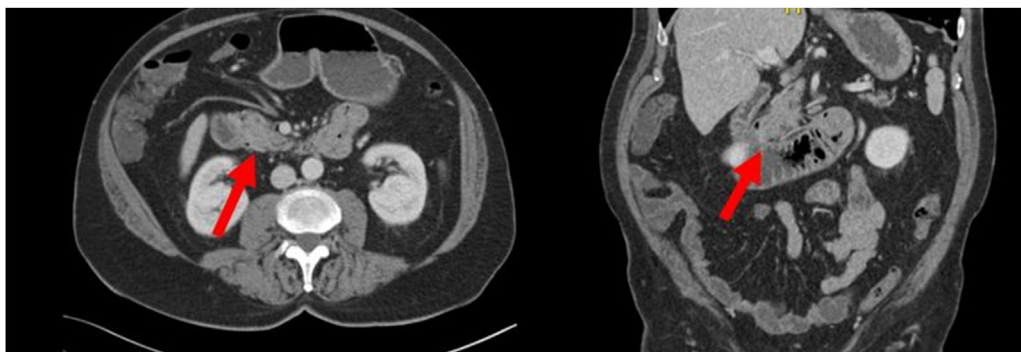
Portal contrast enhancement abdominal CT revealing a duodenal neoplasia (red arrow).
